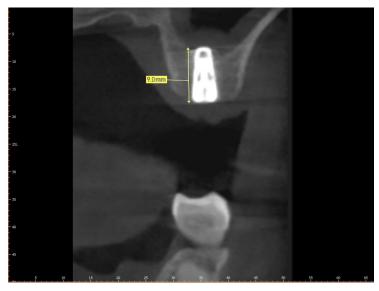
9 mm implant was placed in the position. The CT showed a dome-shaped Schneiderian membrane and a nearly 2 mm increment of the elevation from the sinus floor. The cavity contained injected normal saline, increasing the capacity between the membrane and the sinus floor.
